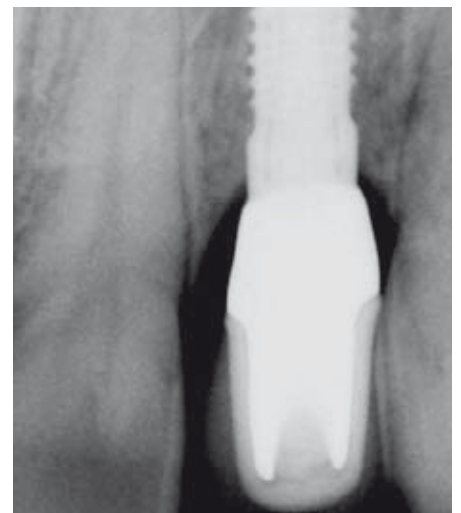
Radiographic control scan (dental film) 32 months after final restoration.
